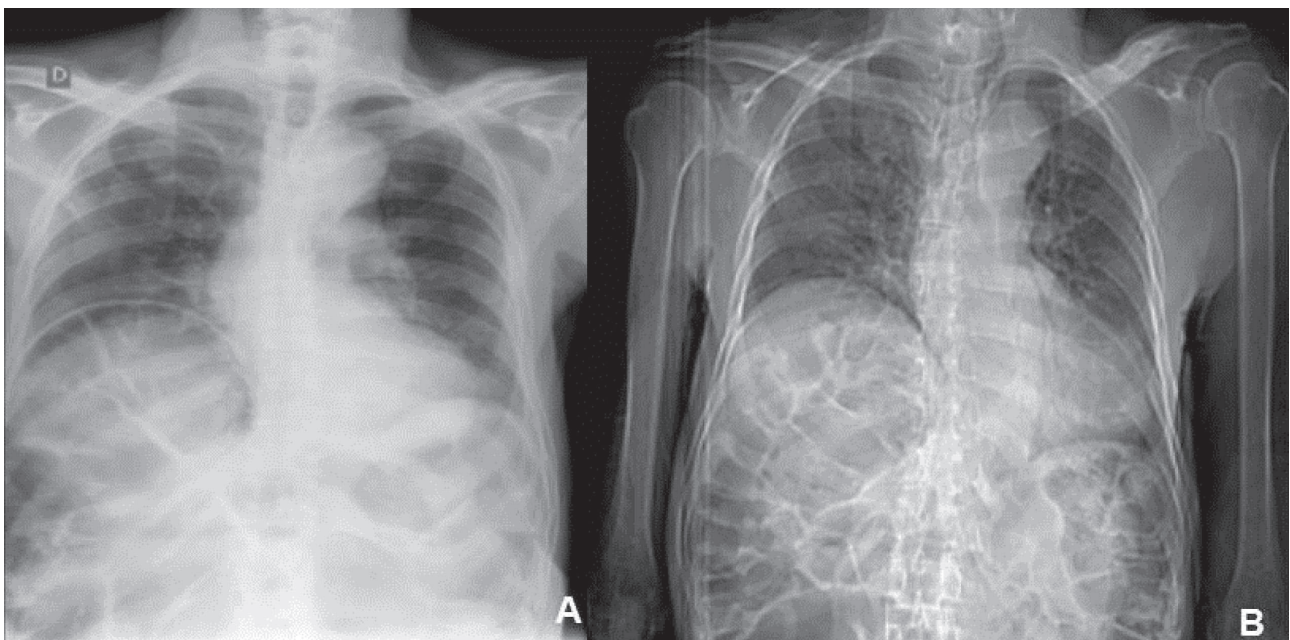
Chilaiditi syndrome in an 84-year-old male: Chest X-ray showing marked dilatation of colonic loops, causing elevation of the right diaphragm (A and B).
